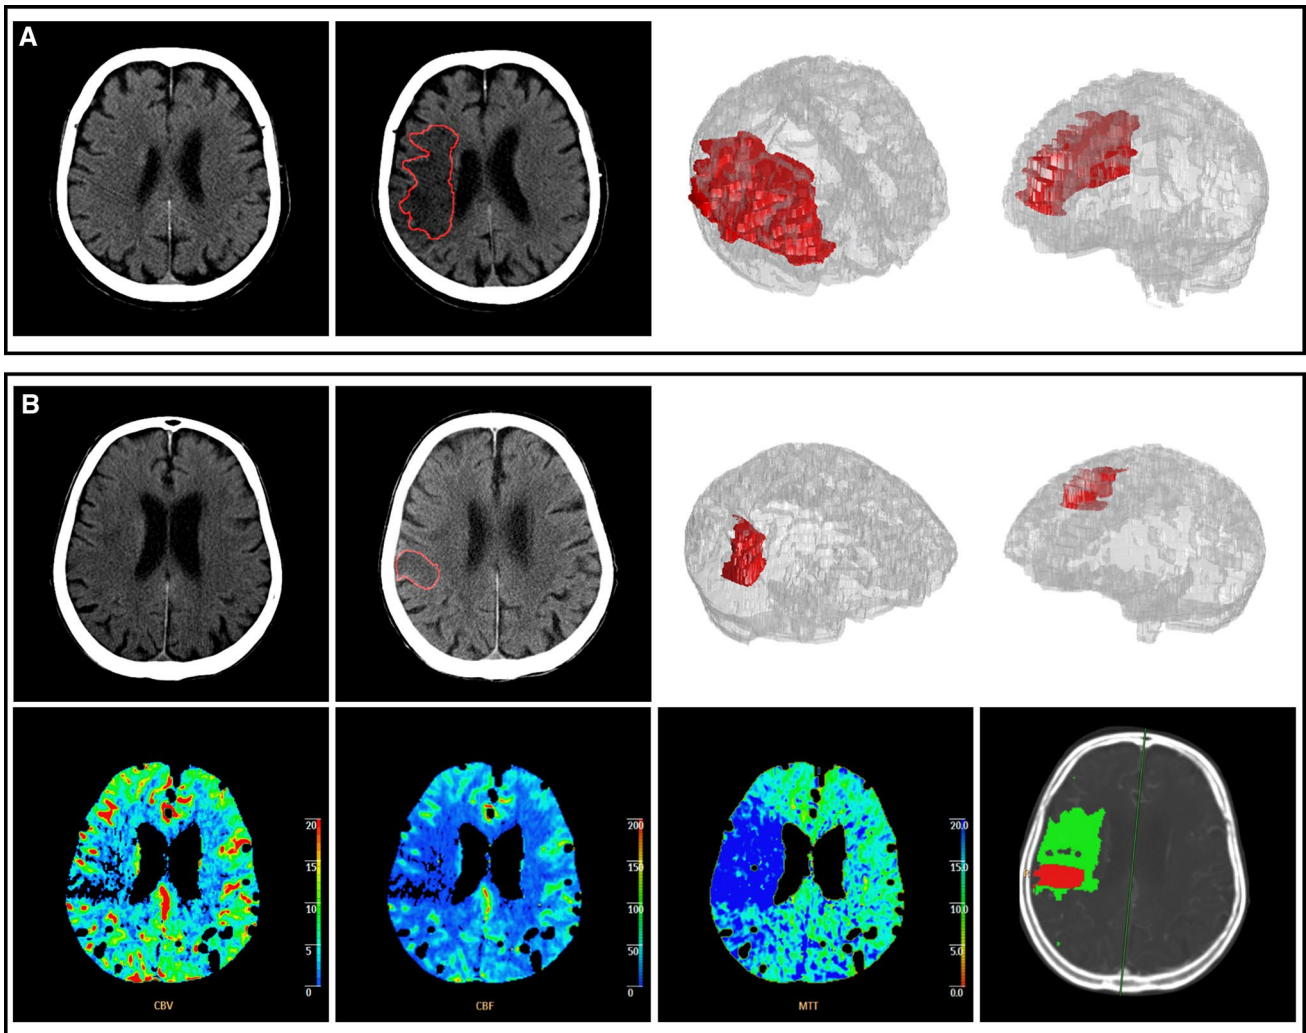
a Non-thrombolised wake-up stroke patient: female, 85 years, ASPECTS=10, right M2-occlusion, PACI, NIHSS at admission=16, premorbid mRS=0, NIHSS at 7 days=16, mRS at discharge=5. From left to right: NECT at admission, follow-up NECT with delineated ischemic lesion, 3D reconstruction of ischemic lesion on follow-up NECT (red). b Thrombolised wake-up stroke patient: female, 84 years, ASPECTS=9, right M2-occlusion, PACI, NIHSS at admission=16, premorbid mRS=0, NIHSS at 7 days=4, mRS
